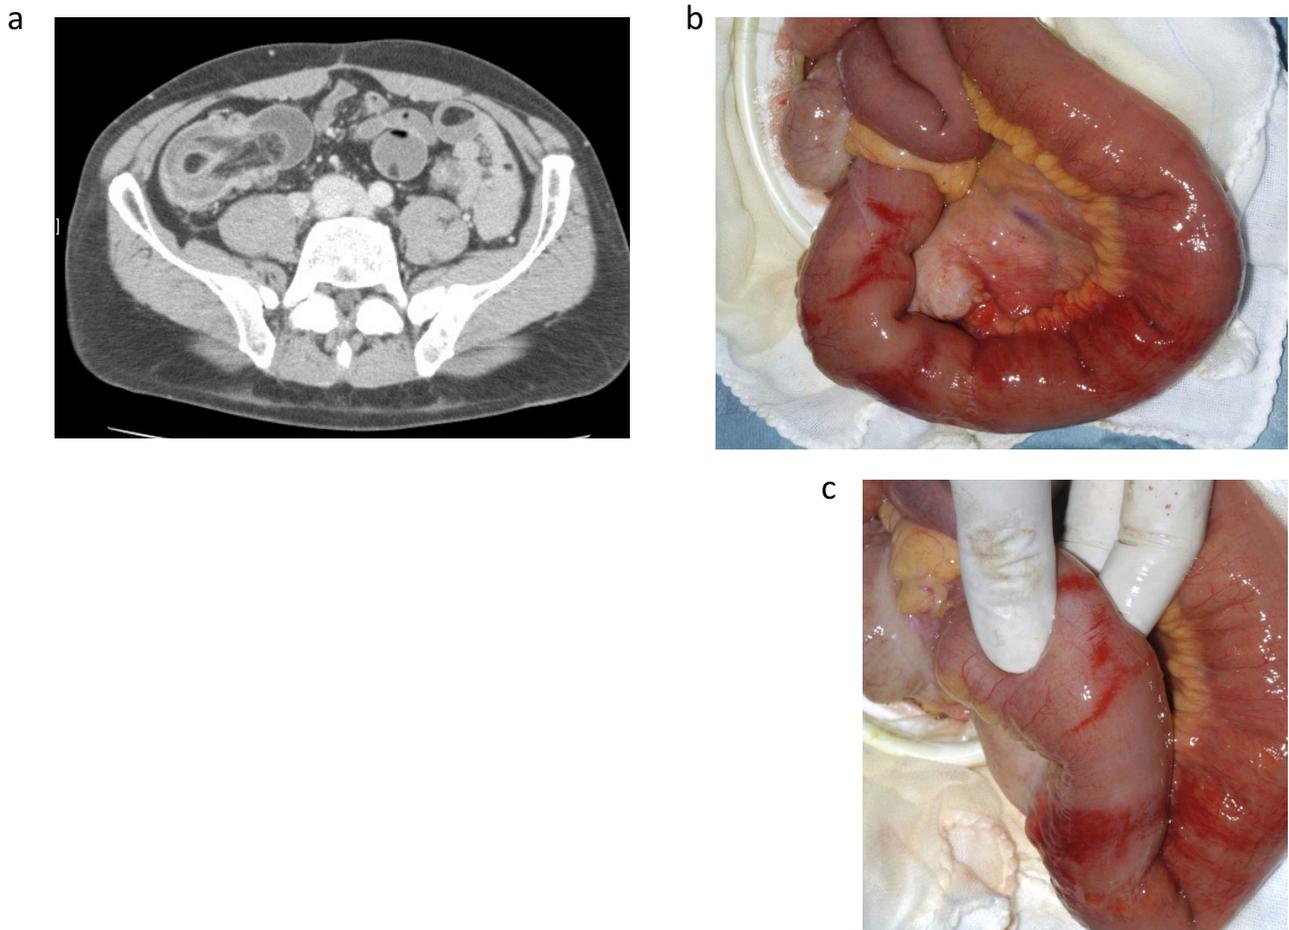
Preoperative CT and surgical findings from the second surgery. (a) Multiple fat-density masses and ileocecal intussusception with leading lipoma are seen on preoperative CT. (b) Previous anastomotic site appears congested and indicates that intussusception occurred near this area. (c) Leading lipoma palpable 6 cm from the ileocecal valve.
